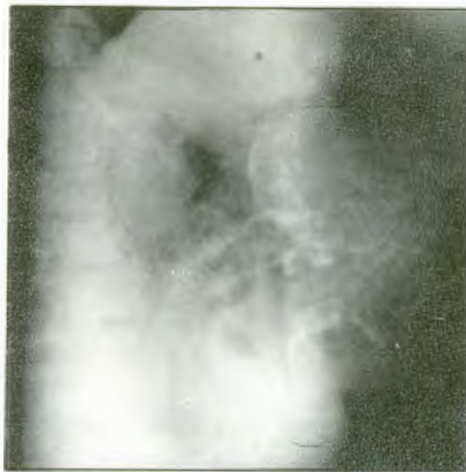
Radiograph showing Spalding's sign in one of the twins
